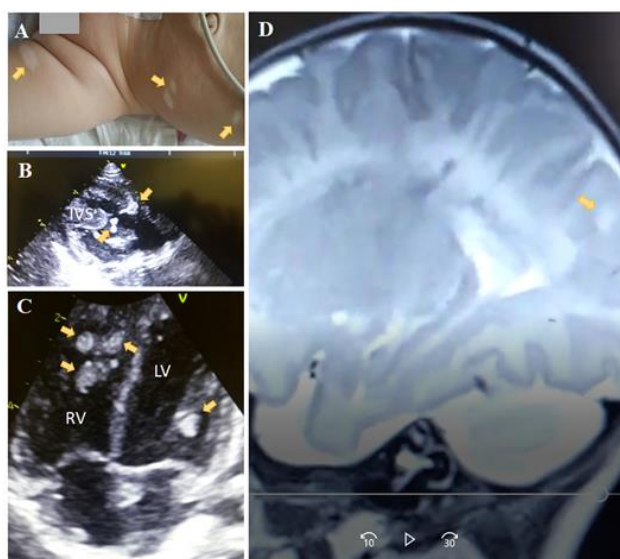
A. Hypopigmented macular cutaneous lesions. 2D transthoracic echocardiographic evaluation through apical four-chamber (B) and parasternal long axis (C) views revealing multiple hyperechogenic masses indicative of rhabdomyoma. D. Magnetic resonance imaging of the brain (T2) revealing an occipital tuber (arrow) indicative of tuberous sclerosis.
